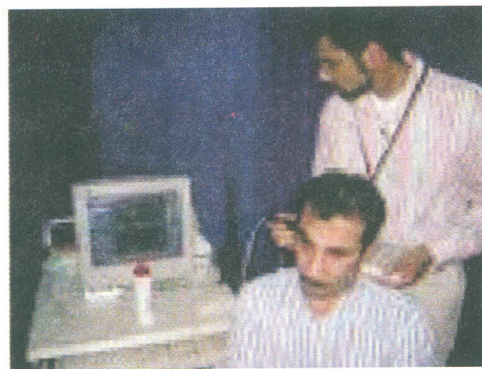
Transcranial Doppler
